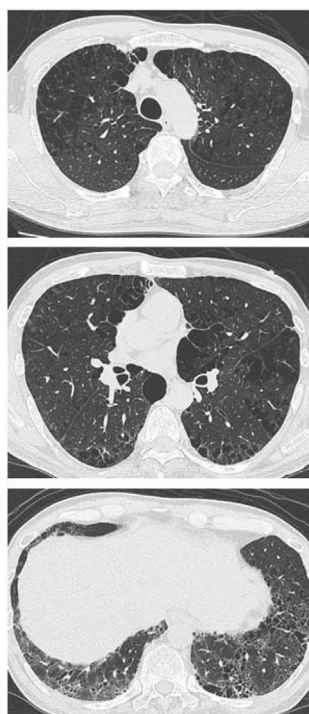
Imaging findings at the initial examination. Chest radiography showed hyperlucency in both lungs and bilateral coarse reticular shadows in the lower lung field. On high-resolution CT, both centrilobular and paraseptal emphysema were seen in the upper lung zones on both sides and bilateral subpleural reticular and ground-glass opacities surrounding the emphysematous cysts were found in the lower lobes.
